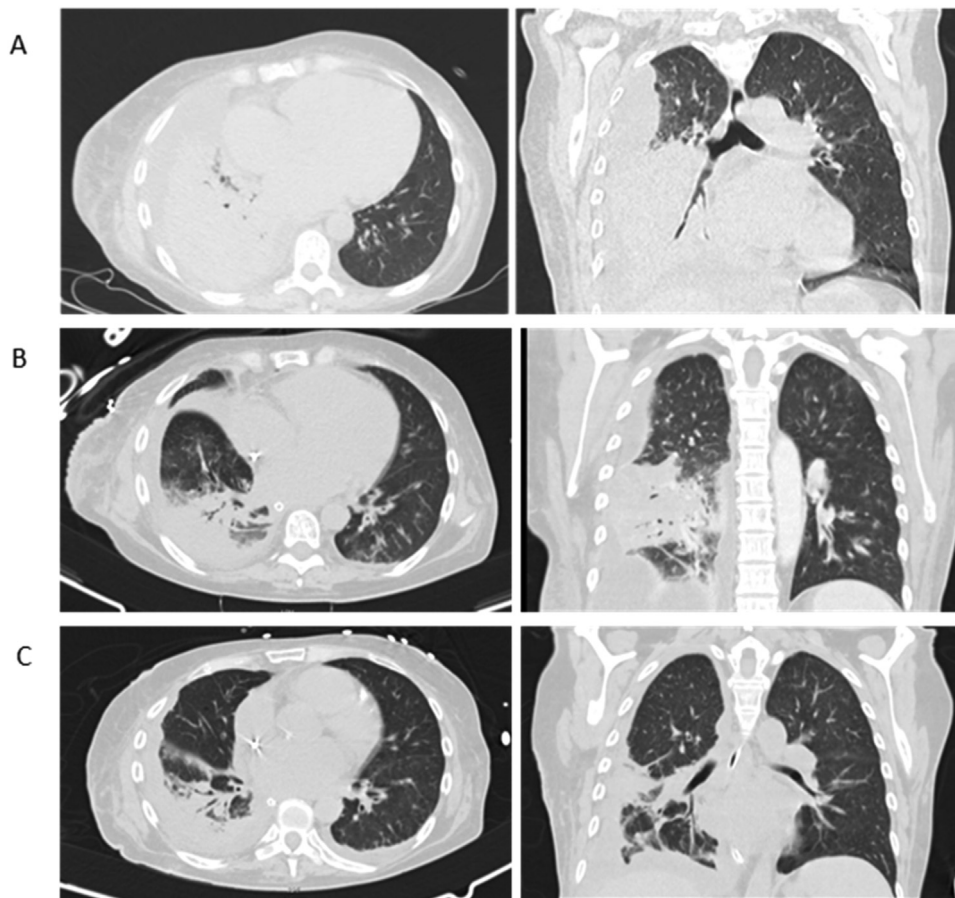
A. Admission lung CT: extensive lung consolidation of the superior and inferior right lobes and large loculated pleural effusion; B. Day 7 lung CT (after chest drainage insertion): large heterogeneous lung consolidation with air bronchogram and gas-filled cavities predominantly in the apical and posterior basal segments of the lower right lobe; C. Day 22 lung CT (after chest drainage repositioning and removal): improvement of lung consolidation extension and pleural effusion, with 16 days of linezolid.
